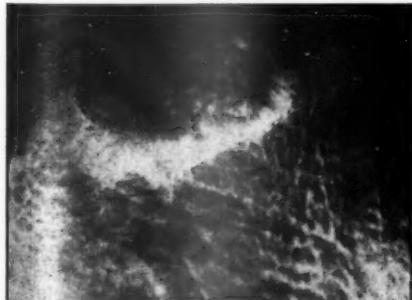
Intra-oral radiograph, $\overline{654}$ region, showing a thick radiopaque shadow encircling a radiolucent area stippled with small opacities.
